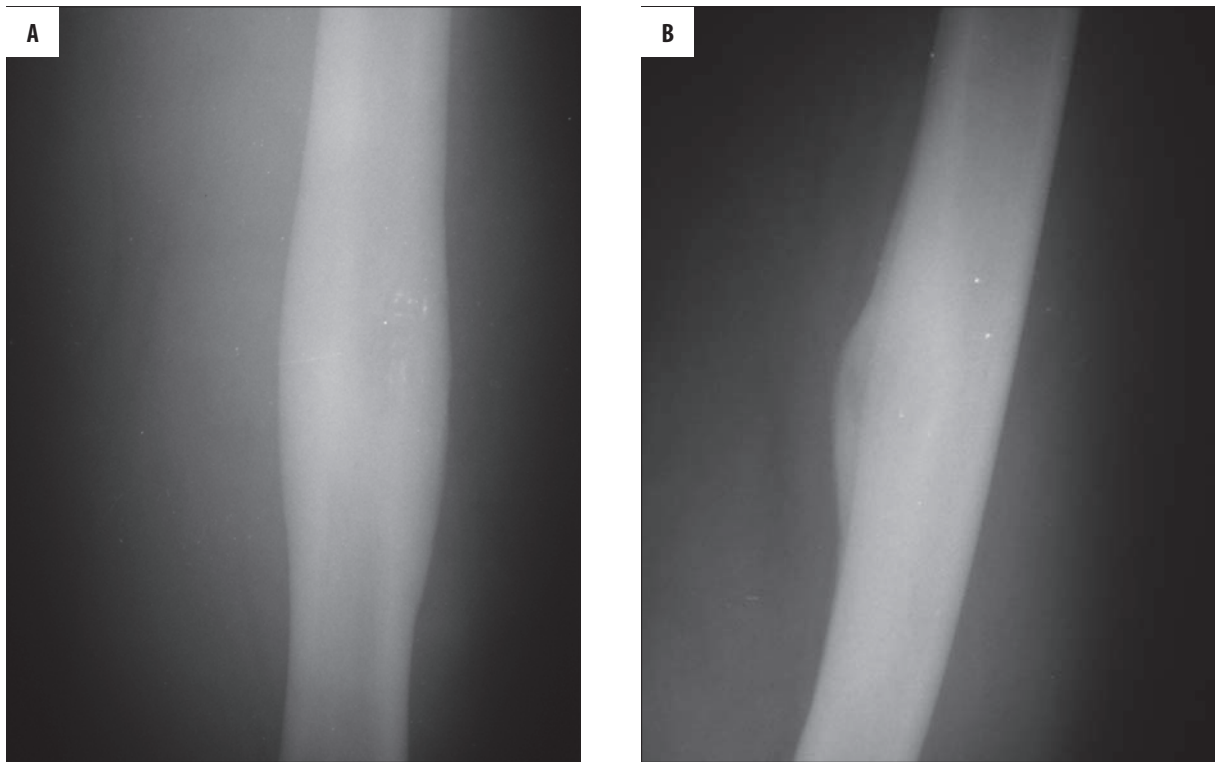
Plain film of the femur. There is an asymmetrical, spindle-shaped thickening of the femoral shaft with osteosclerosis (A,B). In the central part of the lesion, an osteolytic focus is faintly visible (B).
